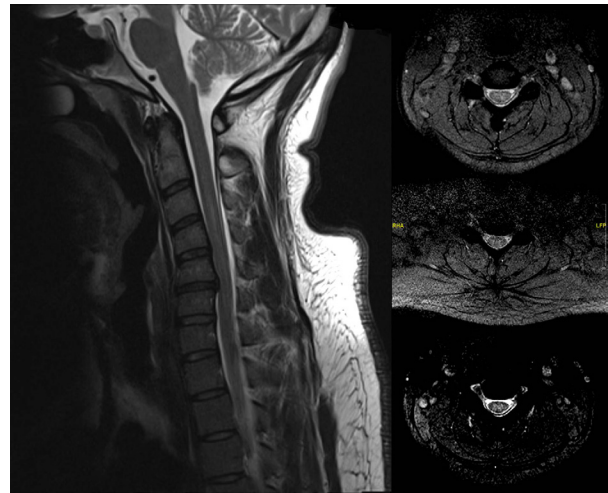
MRI of the cervical spine showing focal non-enhancing lesions extending from C4 to C6.
